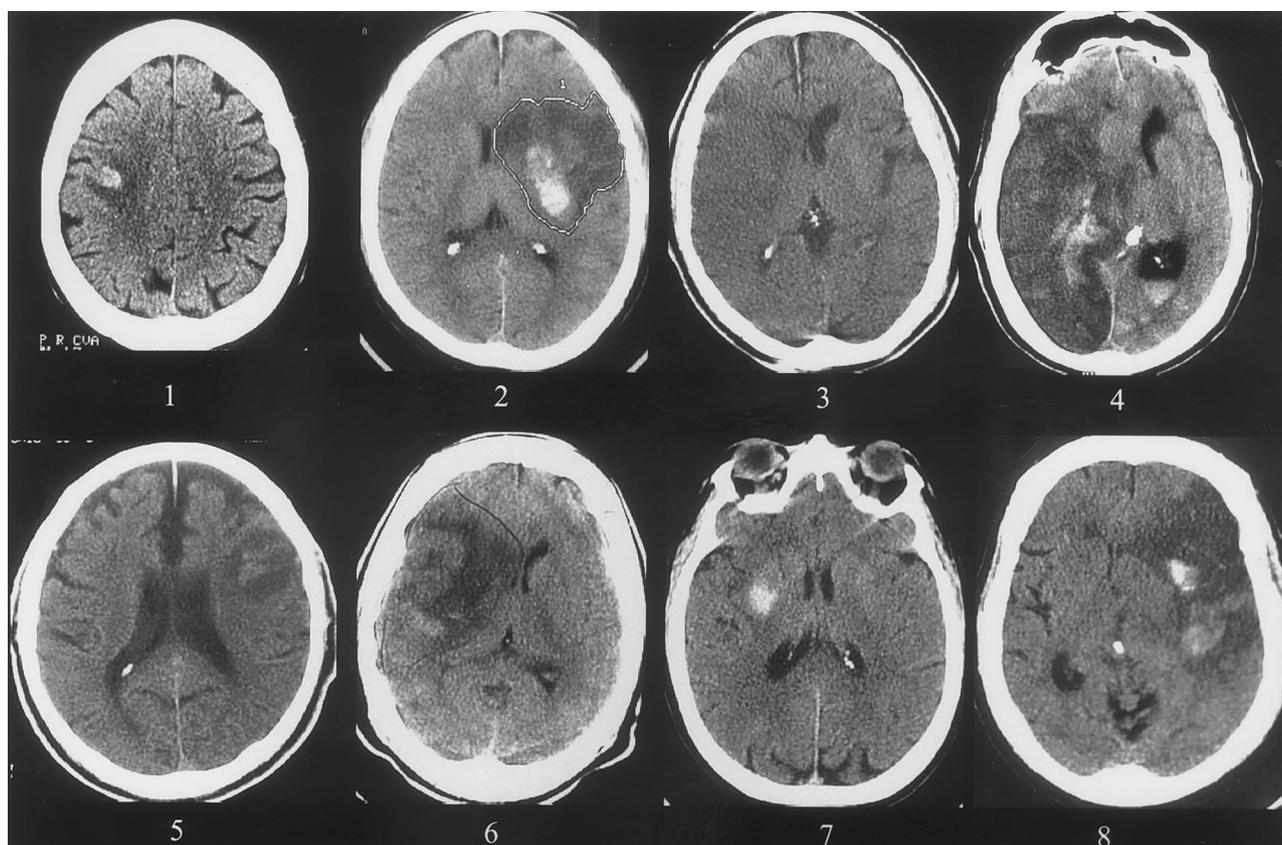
Representative sections of CT scans from all ICH.
